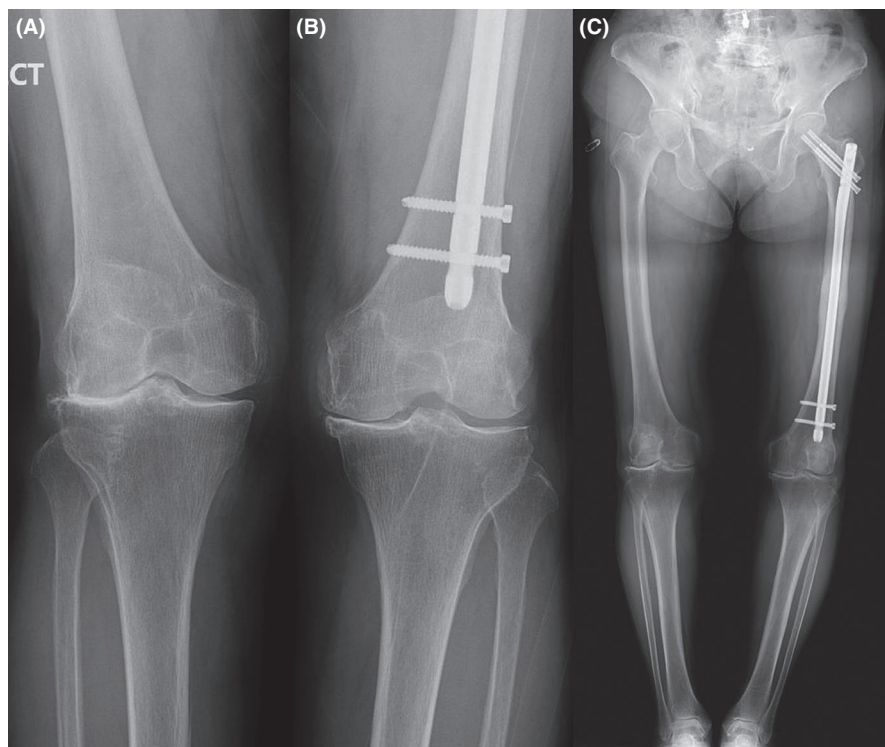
(A and B). Bilateral Kellgren-Lawrence (K-L) grade IV osteoarthritic changes in an 81-year-old woman who failed to respond to conservative management. Three years prior, she had undergone open reduction and internal fixation with an internal medullary nail for a shaft fracture of the left femur. (C) A preoperative standing anteroposterior (AP) radiograph of the bilateral lower extremities shows a right hip-knee-ankle (HKA) angle of 6.2° and a left HKA angle of 11.5°
